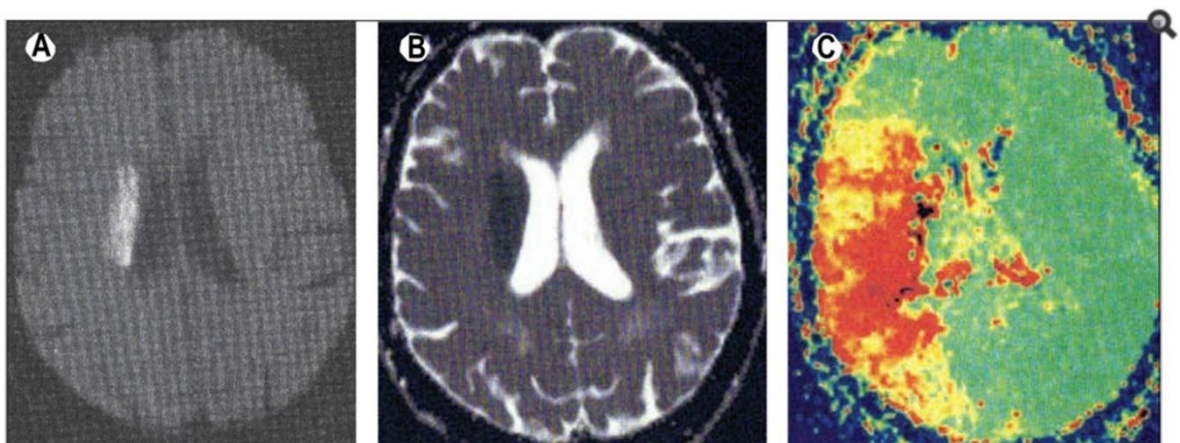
MRI sequences from an 85-year-old woman with a right-sided infarct and a large area of hypoperfusion. The infarct is demarcated on diffusion weighted imaging (A) and apparent diffusion coefficient map (B), large area of hypoperfusion as seen on PWI imaging, demarcated by the area in red (C) Severity of ischaemia correlated with severity of cognitive deficit post-stroke.
